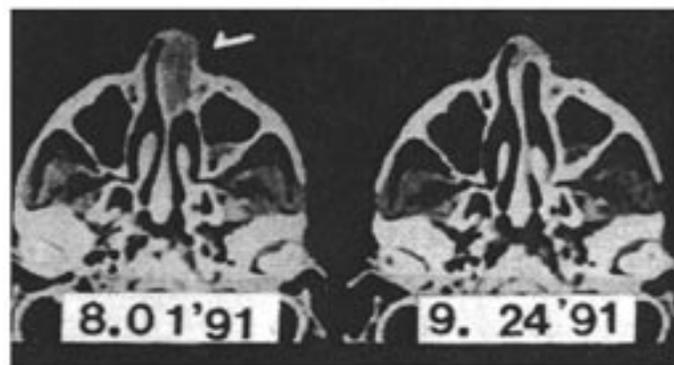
CT scans of upper nasal cavity before and after HBI therapy. Though entirely outside the HBI field, the nasal tumor completely disappeared.³²
